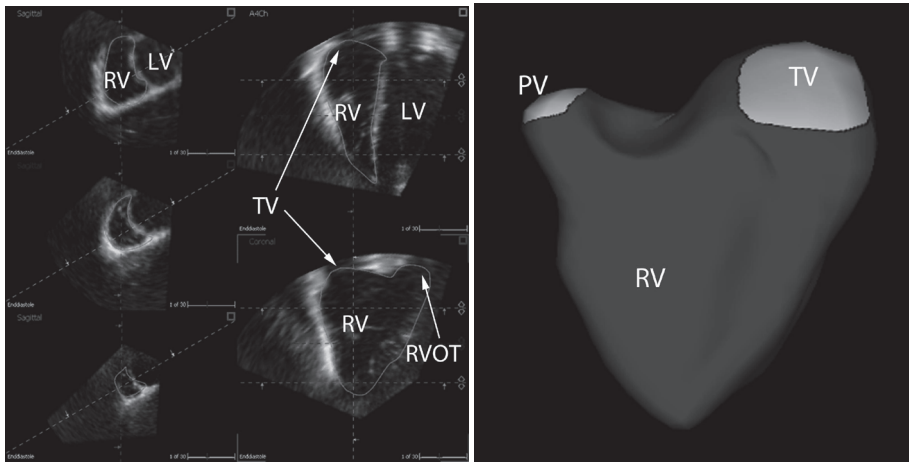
Measurement of right ventricular volume by transthoracic 3DE. (A) Analysis packages designed specifically for the right ventricle are based on user defined reference points and semi-automated tracking of the endocardial border. The green lines show the endocardial border in reference planes including sagittal (left panels), apical projection (upper right panel) and angled coronal planes (lower right panel). (B) Once the user defined planes have been set, a representative model of the right ventricle can be produced, the boundaries of which define EDV and ESV.
